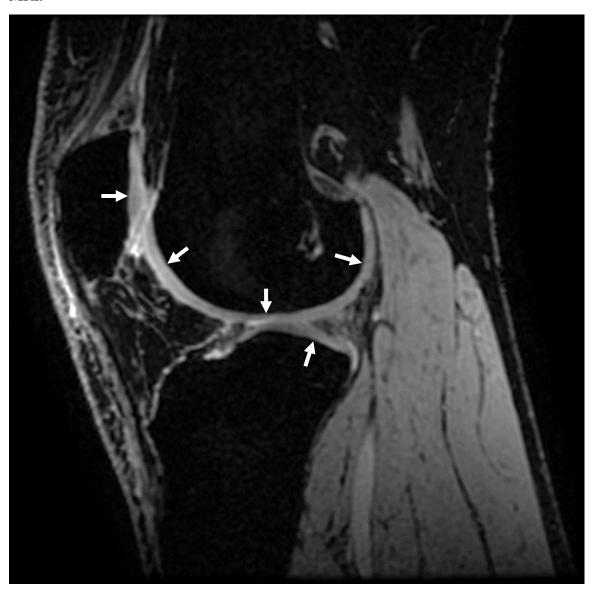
MRI scan of a healthy knee with arrows highlighting the articular cartilage.
